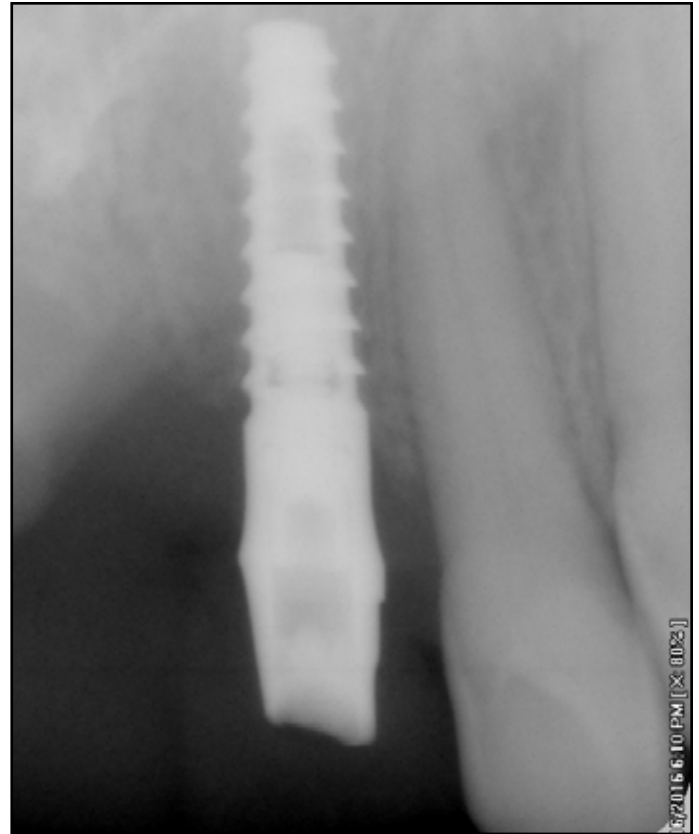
Two years' postoperative periapical radiograph showing the implants in place.
